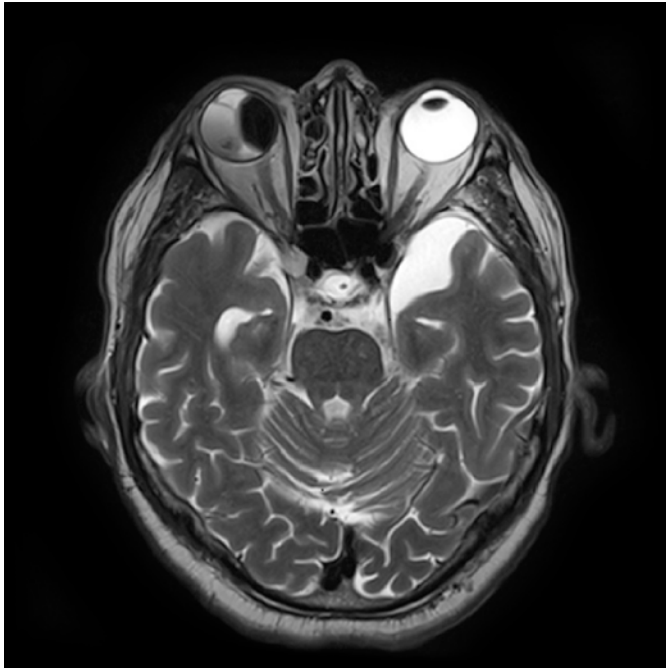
Axial MRI T2 – right hypointense subretinal mass lesion associated with retinal detachment
